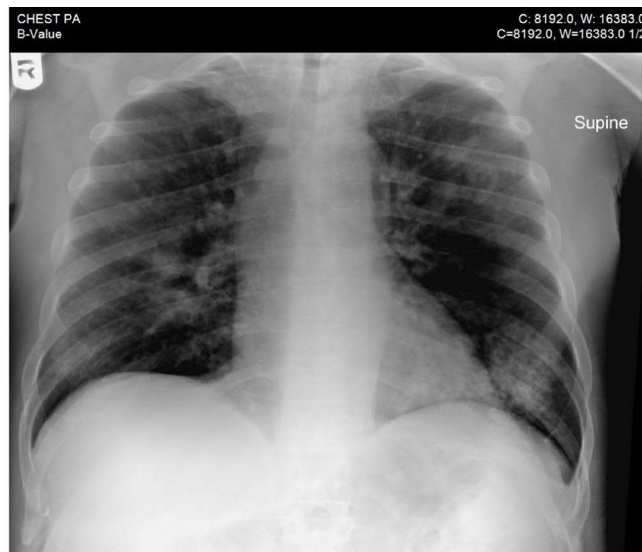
Portable chest radiograph (PA view, supine) of the case 1, revealing bilateral diffuse interstitial infiltrates. The lung fields exhibit a reticulonodular pattern with increased interstitial markings, more prominent in the lower and mid zones, consistent with an interstitial process. Cardiac silhouette and mediastinal contours appear within normal limits. No gross pleural effusion or pneumothorax is identified.
